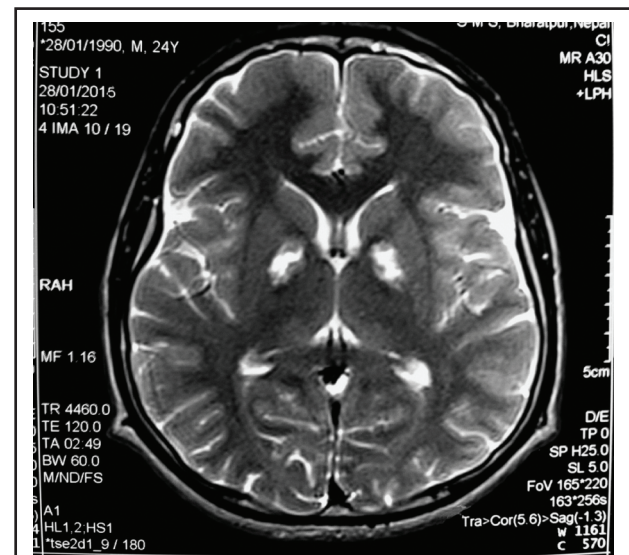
Axial section T2 weighted MRI
